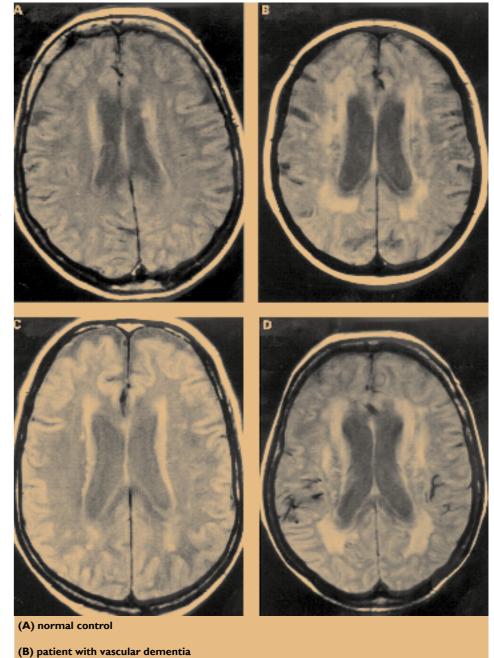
MRI comparing the brain of a normal person and people with dementia
